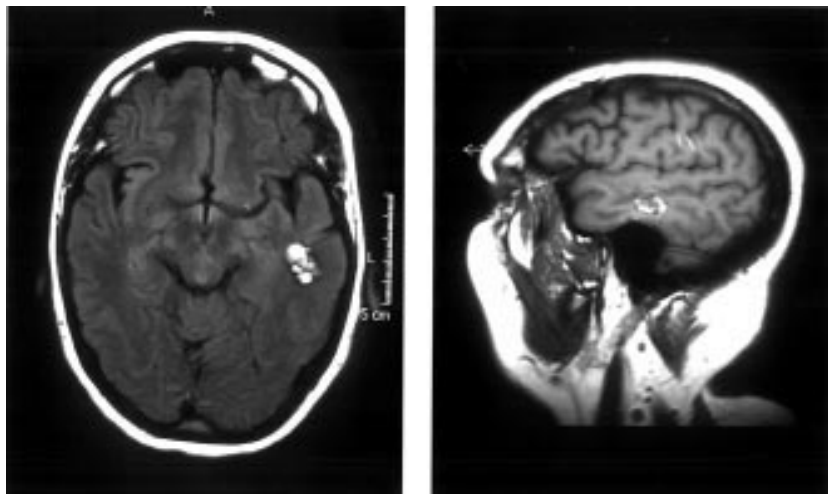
Transverse T2 weighted, fluid attenuated inversion recovery (FLAIR) image (left) and sagittal T1 weighted spin echo image (right). Both show a small popcorn shaped area of increased signal intensity demarcated by a rim of decreased signal intensity (haemosiderin), located in the left medial temporal gyrus. The combination of recent blood products and older haemorrhagic residues is consistent with the diagnosis of a cavernous haemangioma.
